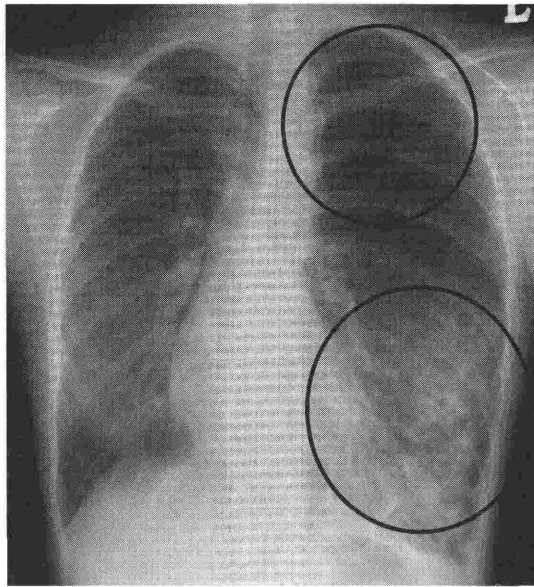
Chest of x-ray film
